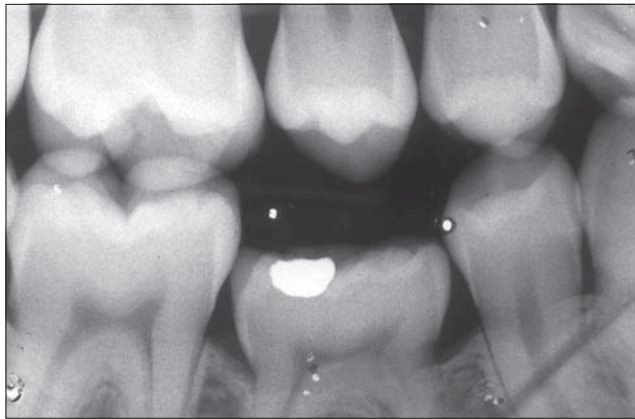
Preoperative radiographic examination. Note the loss of space and tilting of the first permanent molar.
